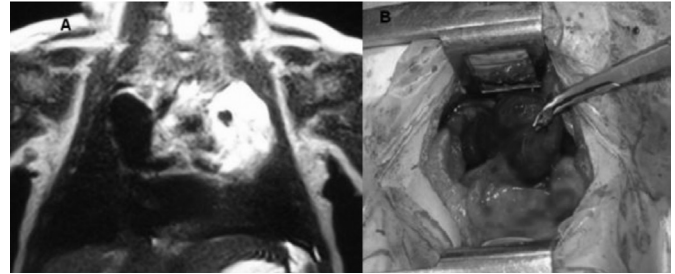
(a) MRI imaging of hyper intense massive lesion which located in left and pushes the mediastinum to right. (b) At operation appearance of the lesion.
